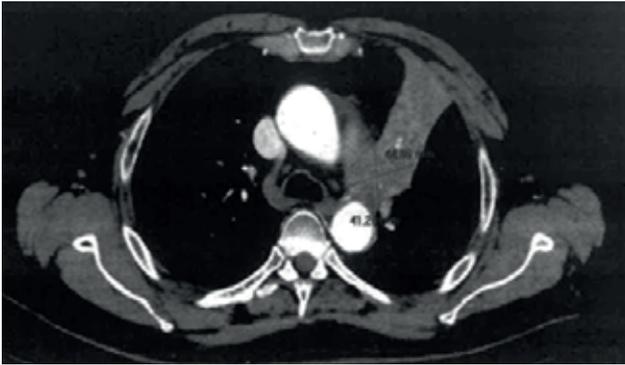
Preoperative axial slice of chest CT that shows the dimensions of the left para hilar mass.
